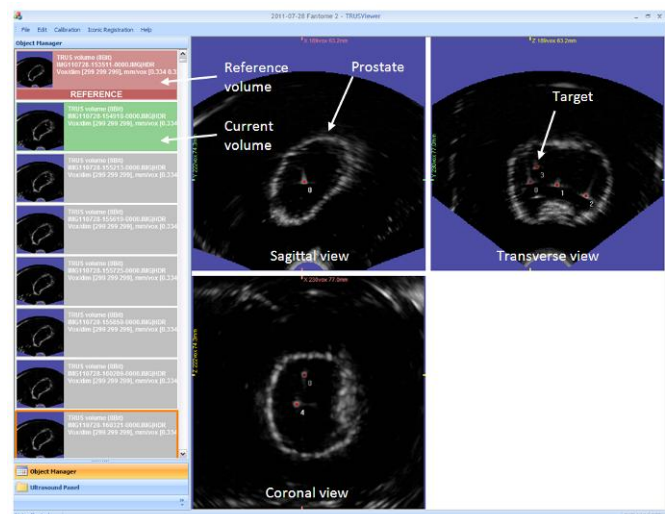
User interfaced for image acquisition with the Ultrasonix 3D probe.
